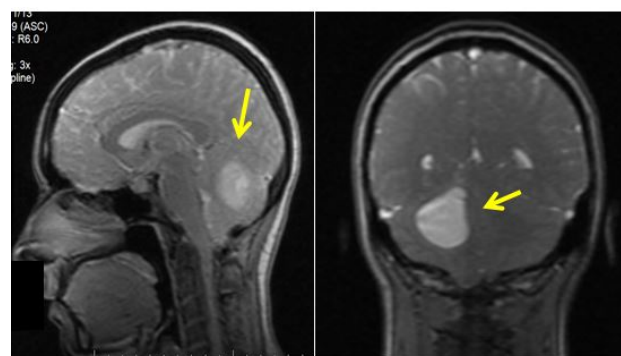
Maternal cranial MRI at week 26
